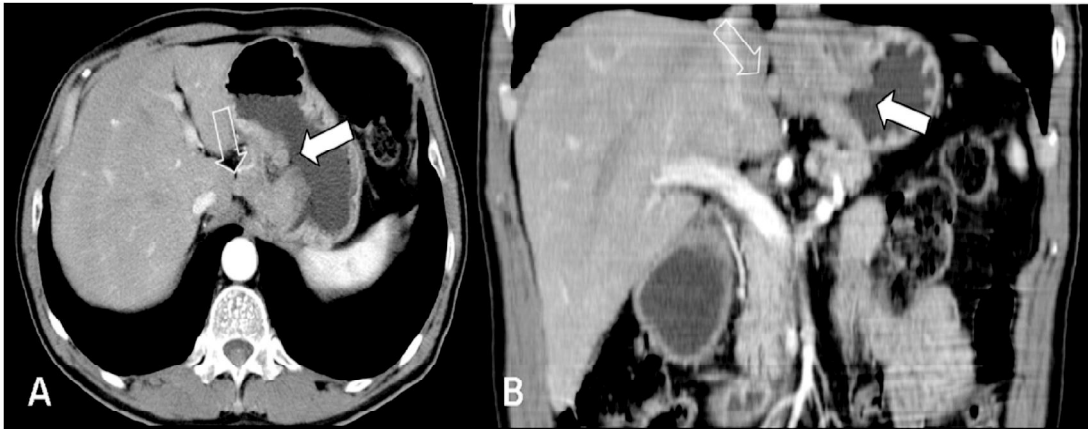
CT scan of whole abdomen showing esophageal growth (Arrow).
